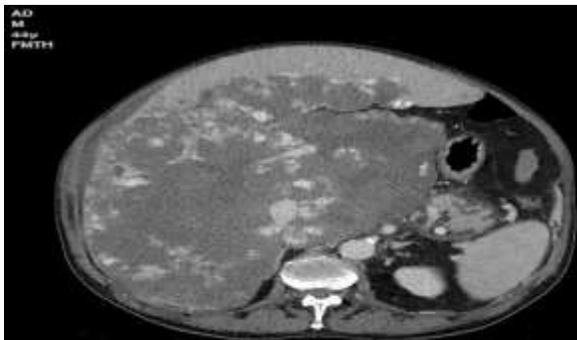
MRI of Liver Hemangioma
